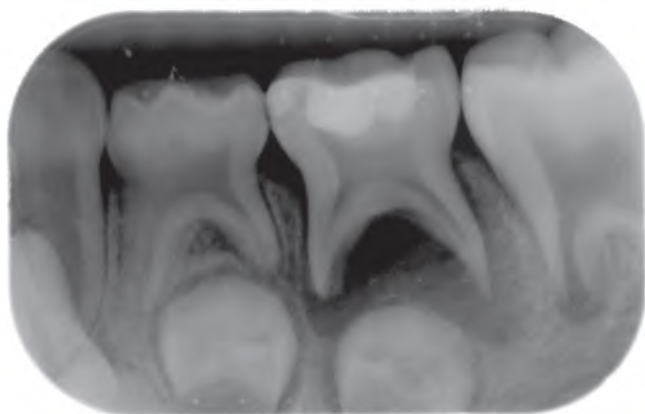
Periapical radiograph of a primary mandibular left second molar after an unsuccessful indirect pulp capping. Note the large interradicular and periapical area that has already affected the bone compacta surrounding the tooth bud of the permanent successor.
